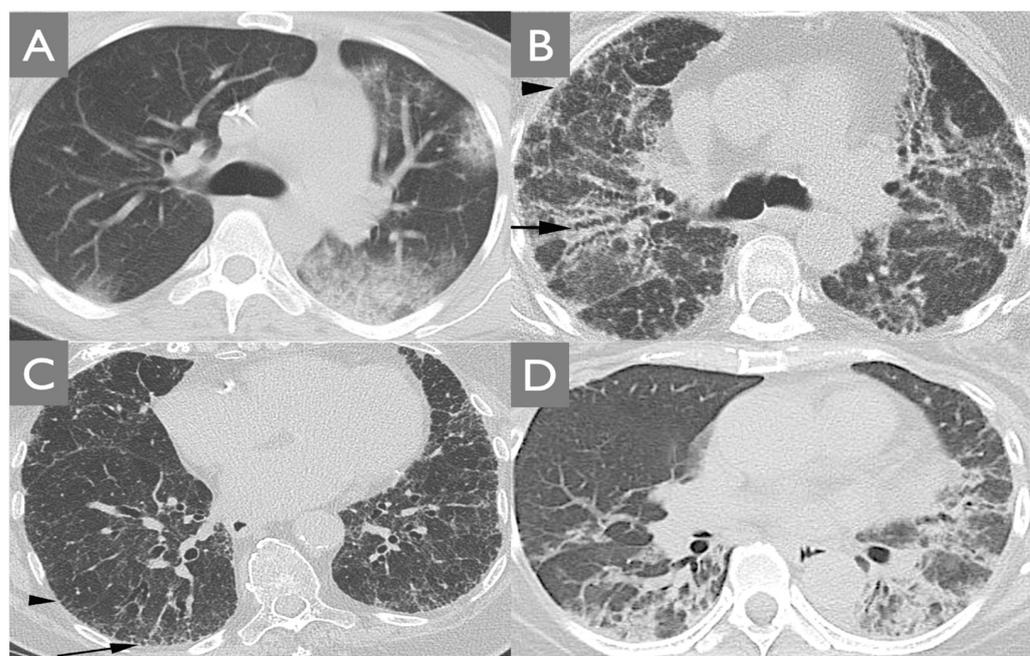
Radiographic patterns of ILD associated with MDA-5 DM. (A) The organizing pneumonia (OP) pattern presents with peripheral areas of ground glass and consolidation. (B) The non-specific
